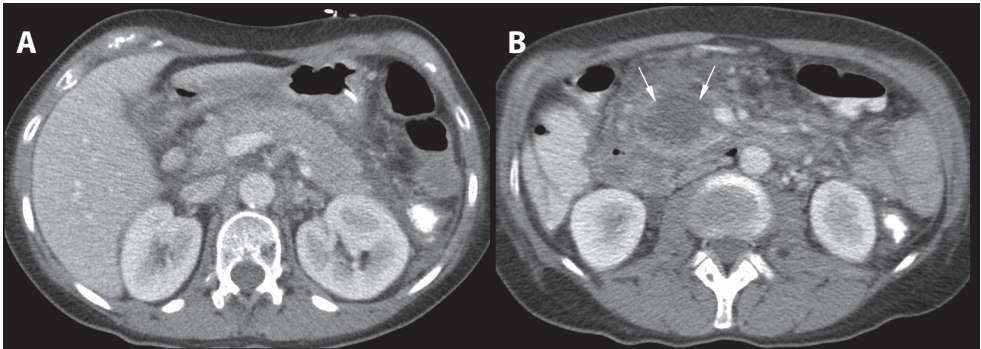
Right sided necrosis – pattern 1. (A) CT showing normal enhancement of pancreatic body and tail, whereas the greater part of the pancreatic head (B) shows non-enhancement (small arrows).
